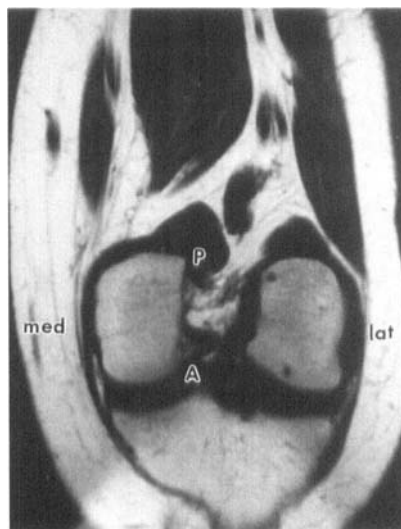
MRI scan parallel with the notch roof at half notch height. Note that the anterior portion of the notch (A) is narrower than the posterior (P).
